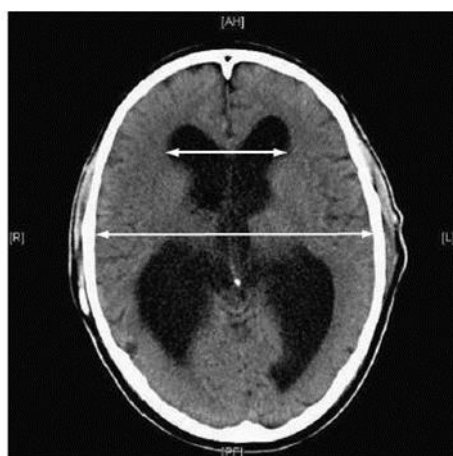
Measurement of ventriculomegaly on axial CT.
